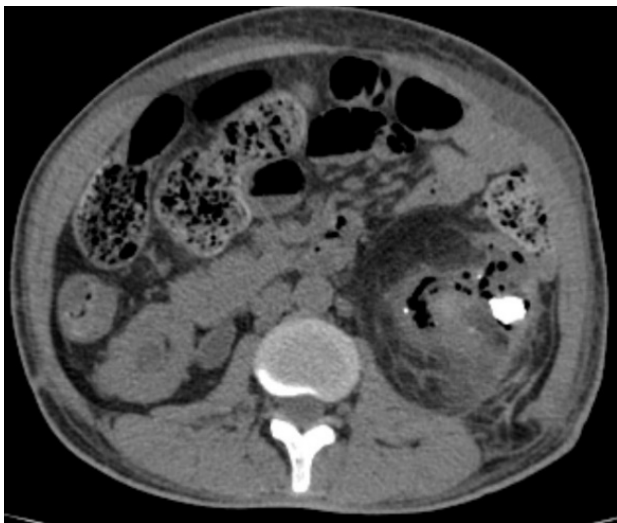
Axial non contrast CT image.
